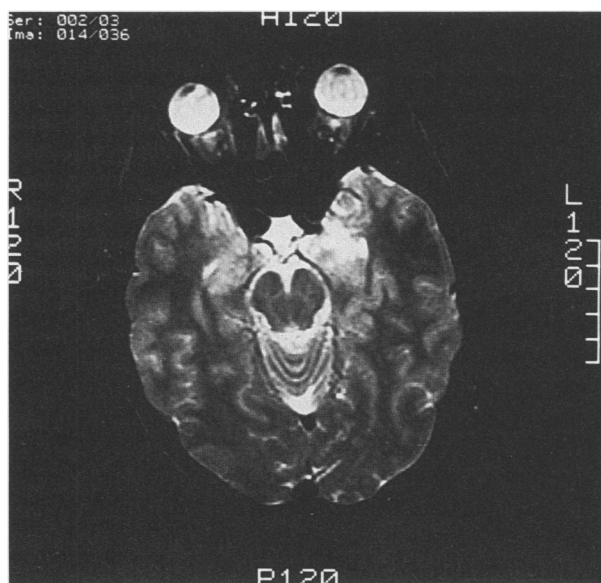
Temporolimbic tumor. Patient 4 had auditory hallucinations for 2 months before the removal of a low-grade left temporal lobe oligoastrocytoma. The small 2-cm lesion shows increased signal intensity on this T2-weighted magnetic resonance imaging scan (TR = 2.0 sec, TE = 80 msec).
